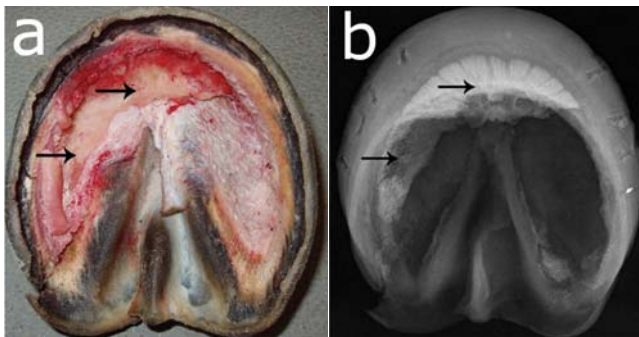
Gross examination (a) and radiograph (b) of the avulsed hoof at time of presentation. The dorso-lateral fragment of the third phalanx (arrows) is embedded in the avulsed hoof.
